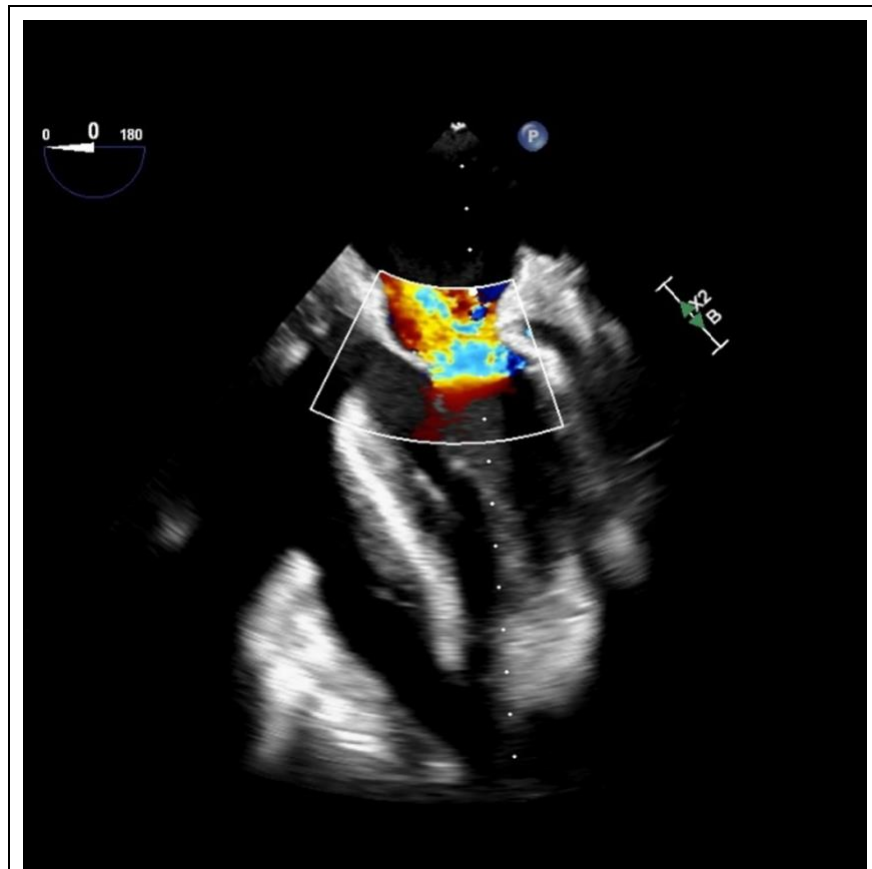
Mid-esophageal 0° transesophageal echocardiography demonstrating acute regional left ventricular dysfunction with secondary mitral regurgitation.
